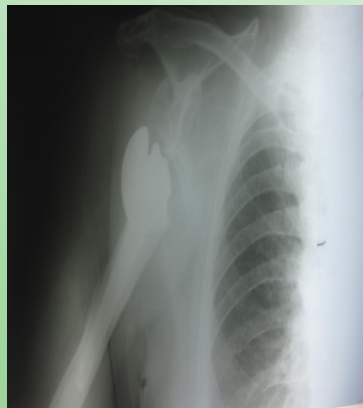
Antero-posterior Radiograph of the Shoulder Showing the Disengagement of the Humeral Head Component of the Prosthesis.
